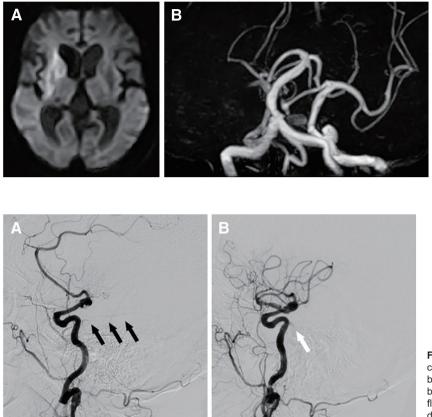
Head MRI and MRA just before thrombectomy. Diffusion-weighted images show high intensity of the right basal ganglia (A), and MRA shows occlusion of the M1 segment of the MCA (B). MCA: middle cerebral artery
